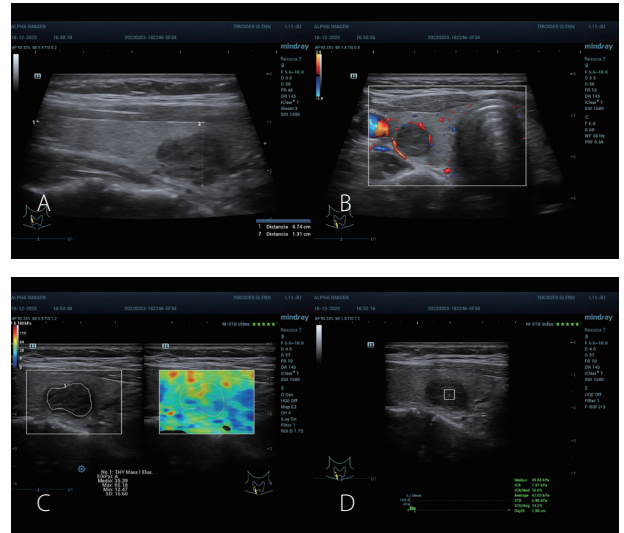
A: Nodule in the lower right third, maximum diameter 2.0 cm, ACRT 4. B: Peripheral Doppler vascularization, AS moderate suspicion, TE RT SWE Emean and Emax with kPa below C/O. D: pSWE kPa below C/O, MIQR 16%, ROI box 3 x 3 mm, depth 1.6 cm. Result: cytopathological Bethesda: II, benign.
